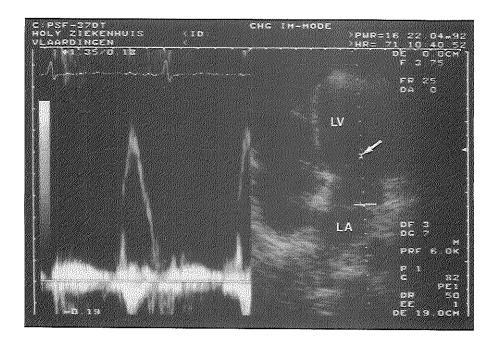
Precordial echocardiographic apical four chamber view and pulsed Doppler recording of transmitral flow with the sample volume placed at the tips of the mitral valve leaflets (arrow). LA= left atrium; LV= left ventricle.
